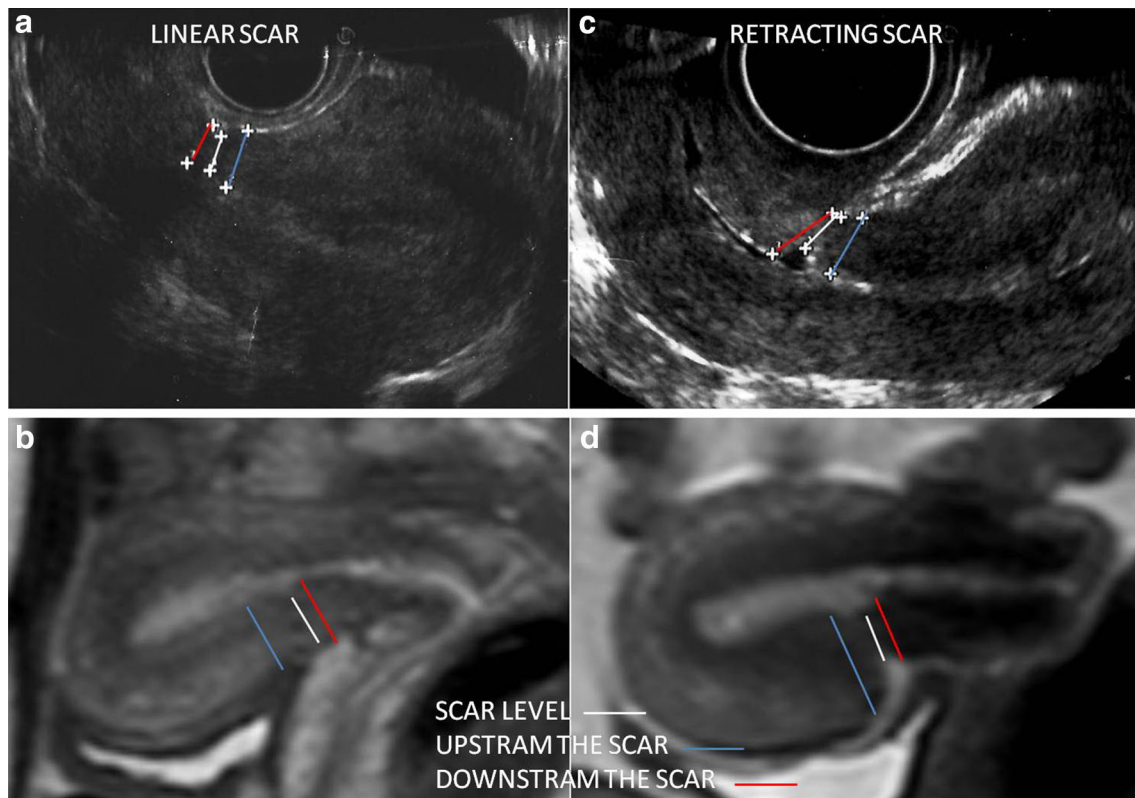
Morphological subjective description of the caesarean scar; comparison between transvaginal ultrasound (TVUS) and magnetic resonance imaging at 3 Tesla (3T-MR); myometrial thickness
